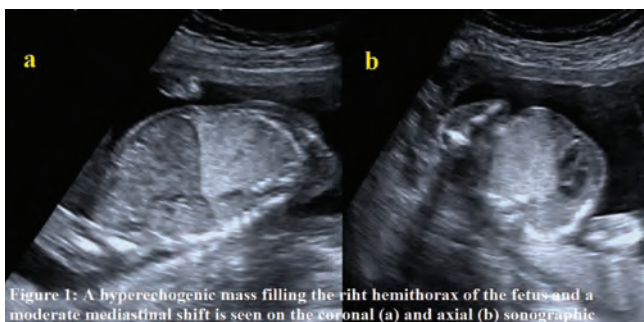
A hyperechoic mass filling the right hemithorax of the fetus and a moderate mediastinal shift is seen on the coronal (a) and axial (b) sonographic
